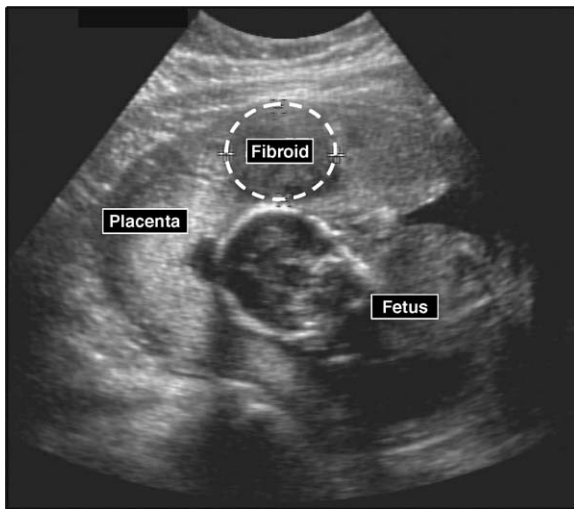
Retroplacental fibroid. A transabdominal ultrasound image of an 18-week pregnancy is shown. The placenta is located anteriorly. The fetus is in the breech position. A large (3.6 × 3.3 cm) submucosal fibroid can be seen behind the placenta.
